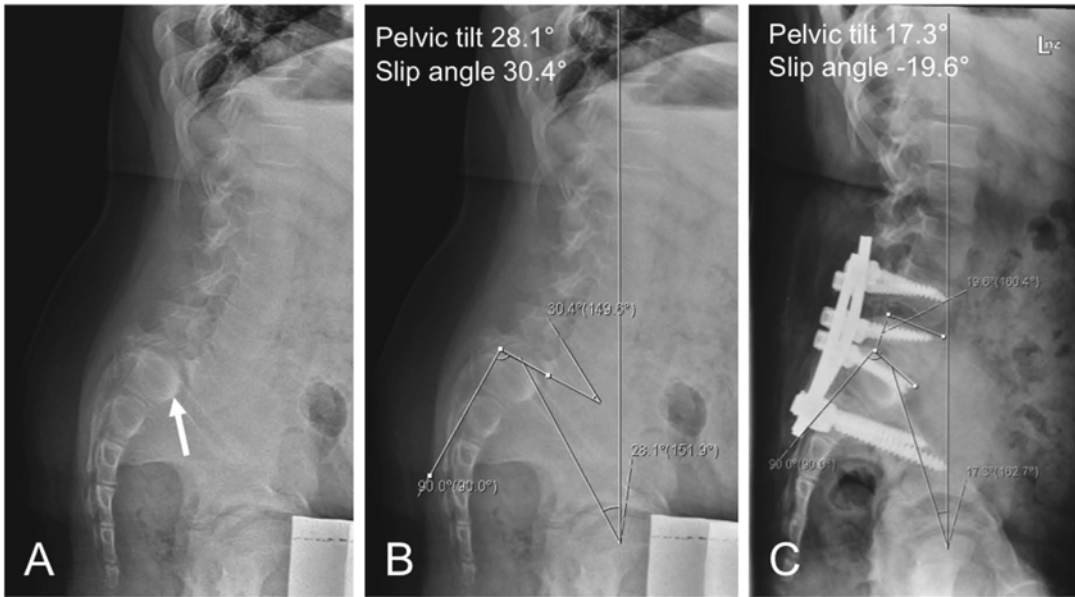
(a) Sagittal radiograph of the lumbar spine showing morphologic changes at the S1 endplate (*arrow*) as a result of progressive spondylolisthesis at L5–S1. (b) Pre-operative sacropelvic parameters showing increased
